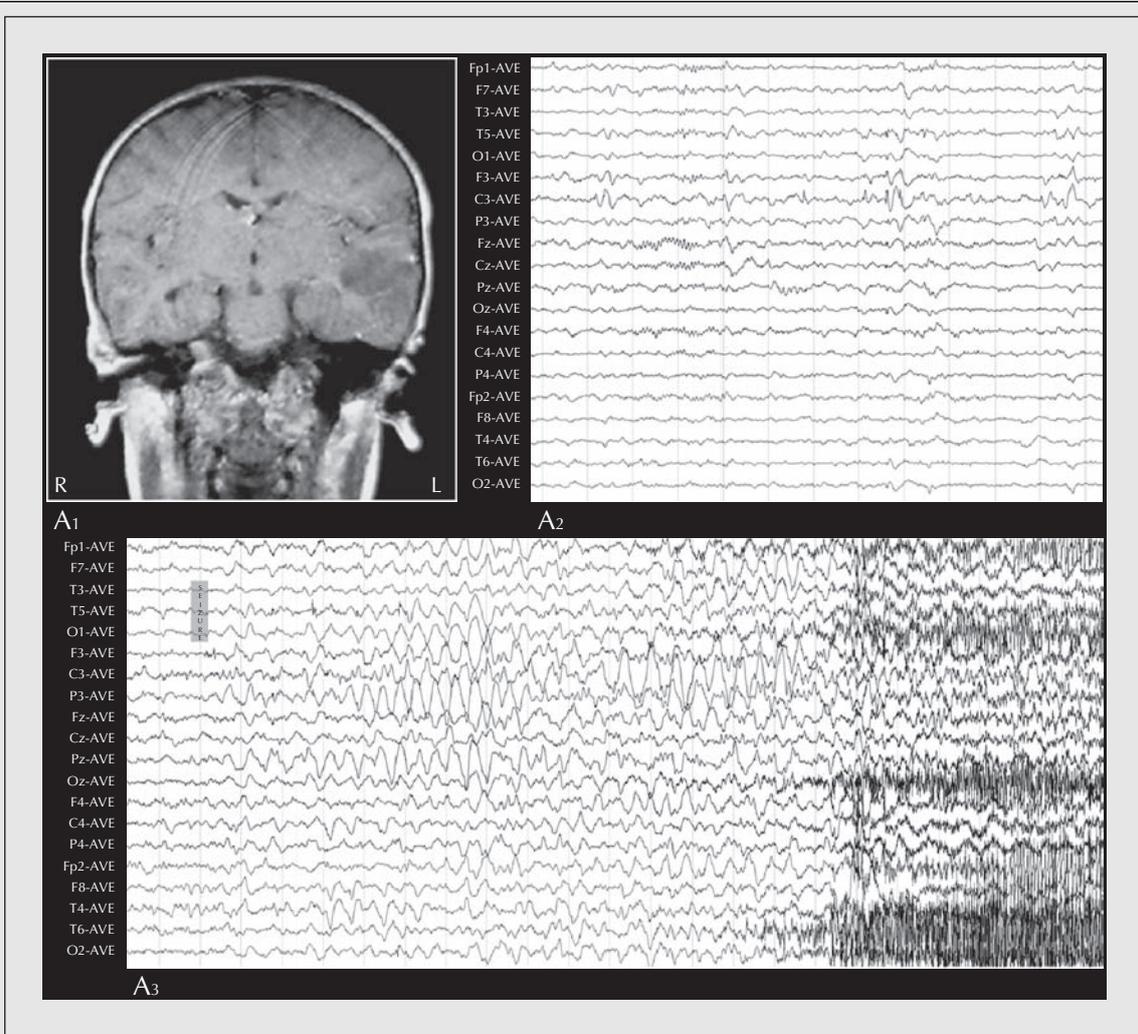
Patient 6. (A₁) MRI showing a left temporal lobe tumour invading the basal temporal and inferior lateral temporal neocortex. (A₂) Interictal EEG shows a well-localised SW focus over the left central region (C3). (A₃) Ictal EEG onset is broader, less well-organised, with a left-hemispheric rhythmic delta pattern, prominent over the parasagittal region (C3 and P3/Pz).
